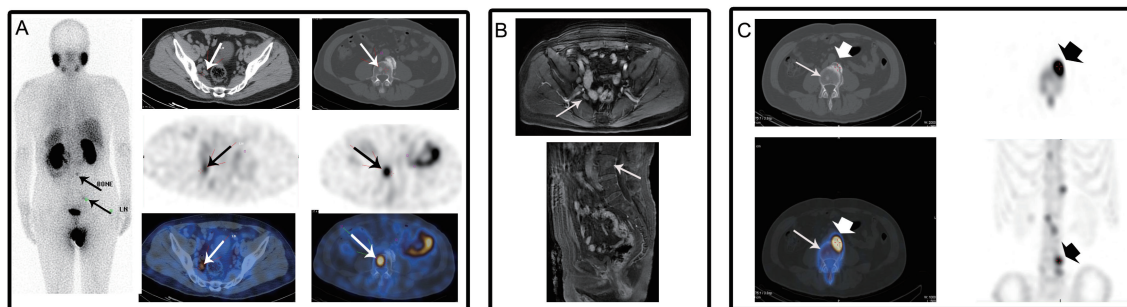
^{99m}Tc -PSMA SPECT/CT、MRI和 ^{99m}Tc -MDP SPECT/CT对前列腺癌转移灶的检测
